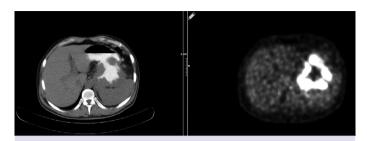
Image of positron emission tomography computed tomography, locally advanced gastric hepatoid carcinoma (SUDmax: 18.6).
